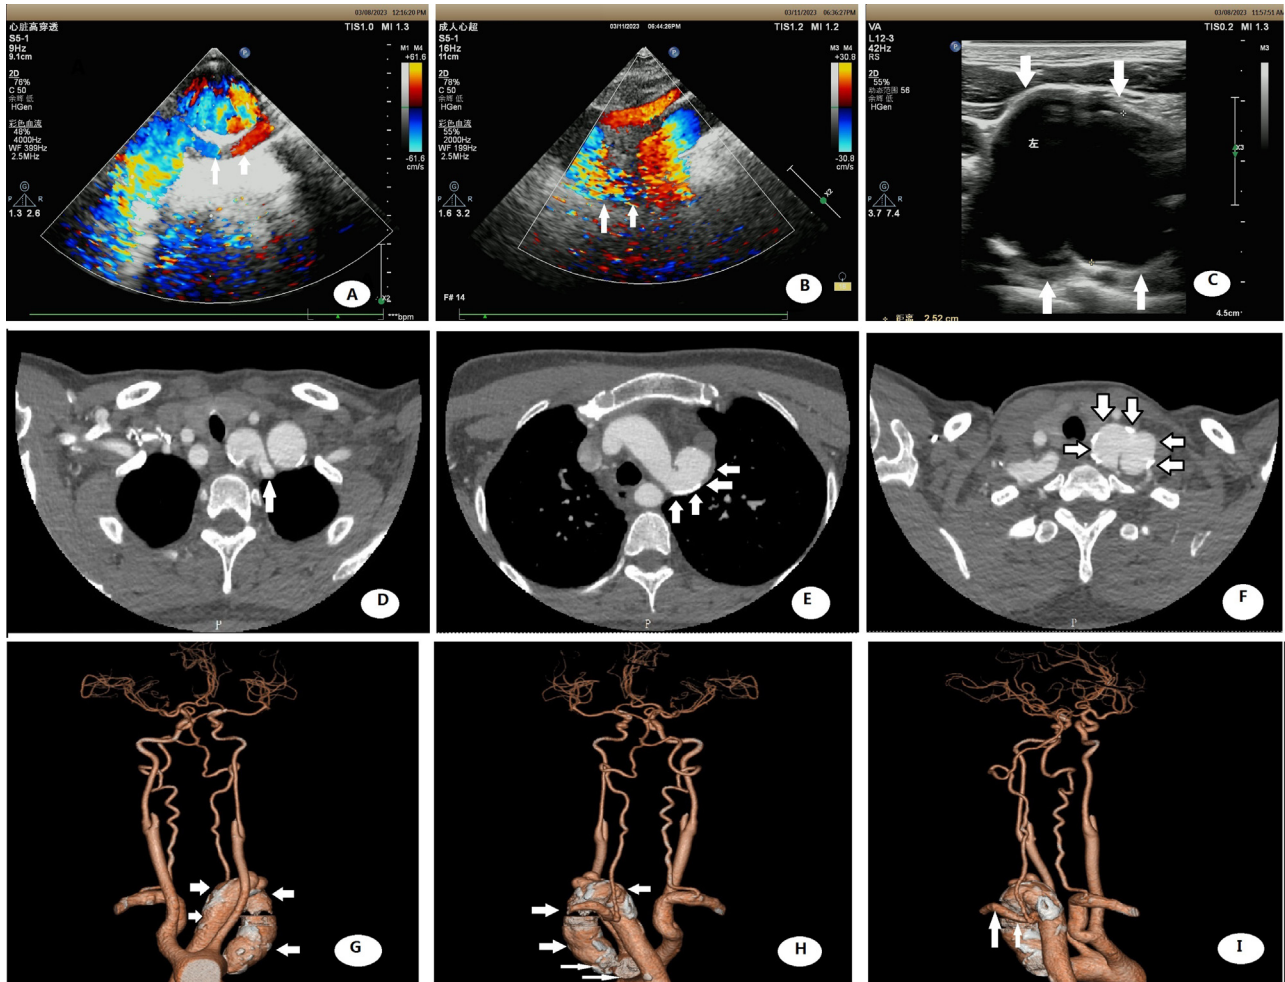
Dysplasia of the distal arch of aorta accompanied by multiple aneurysms. (A) From the distal end of the aortic arch to the left neck turn back, the whole process was neoplastic expansion, and the left subclavian artery could be seen from the lower part of the turning point (white arrow). (B) The turning point where the distal end of the aortic arch reversed upward (white arrow). (C) The distal aortic arch curved upward to the left neck and turned back, forming an aneurysm with atherosclerotic plaque attached to the wall (white arrow). (D) The origin of the left subclavian artery could be seen from the distal end of the aortic arch to the descending part of the cervical reentry (white arrow). (E) The position of tortuous upward turned in the distal segment of aortic arch (white arrow). (F) The turning point where the distal end of aortic arch bent upward to the left neck and turned back, and an aneurysm was formed (white arrow). (G) From the front view of the neck CTA, the distal segment of the aortic arch twisted and turned up to the left neck, and then turned back down to continue to the descending aorta (white arrow). (H) Looking behind the neck CTA, the distal end of the aortic arch twisted and went up to the left neck, and then turned back to the descending aorta (white arrow). (I) From the right back of the neck CTA, the distal end of the aortic arch twisted upward, and then turned to the descending aorta, from which the left subclavian artery could be seen (white arrow).
